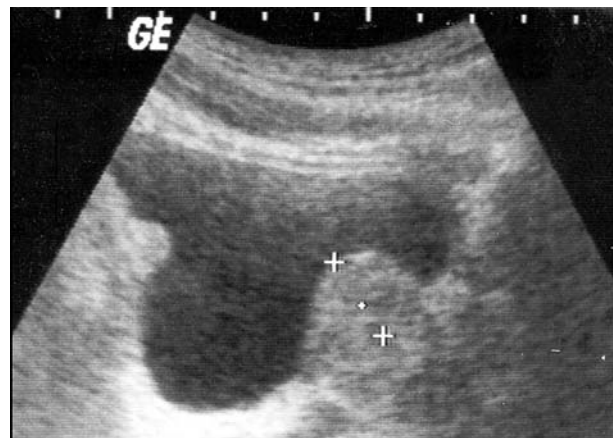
Sagittal views of bladder and prostate using transabdominal ultrasonography. Vertical distance from tip of protrusion to base of bladder is the intravesical prostatic protrusion measurement.
